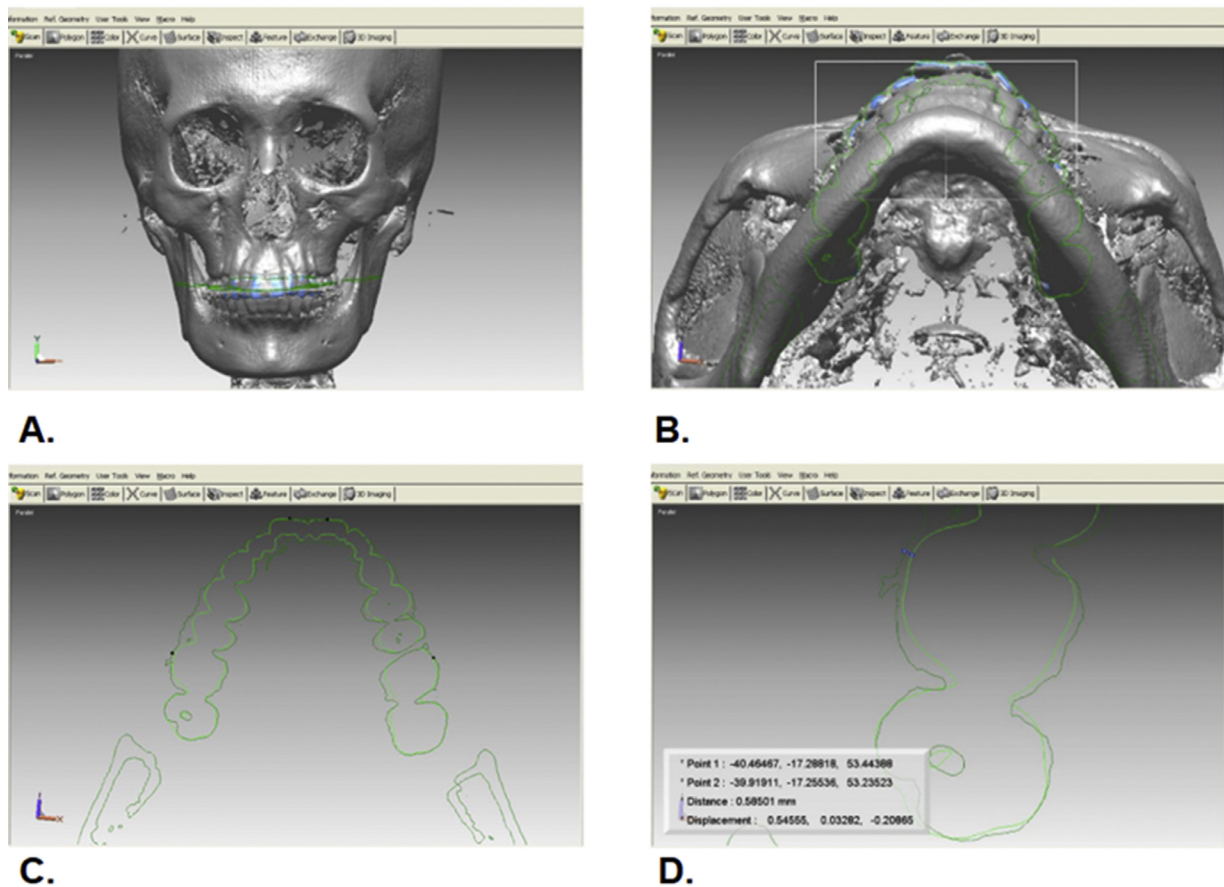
Measurement of the discrepancy between the CBCT and the intraoral images on the cross-sectional plane. A, Construction of the cross-sectional plane using 3 points: The incisal one-third of the maxillary central incisors’ interproximal area and the occlusal half of the right and left first molars. This plane also crosses the superimposed intraoral scans. B, Rotation of the superimposed images to see the cross-sectional view. C, The green line indicates the cross-section of the CBCT image, and the light green line indicates the cross-section of the intraoral scan image. D, The discrepancy between the CBCT and intraoral images was calculated by selecting a point on the CBCT image. Once a point is selected on the CBCT image, the corresponding point on the intraoral image is automatically represented. The actual distance between these 2 points is expressed as “Distance,” whereas the difference in the x-, y-, and z-directions is expressed as “Displacement” in the program.
